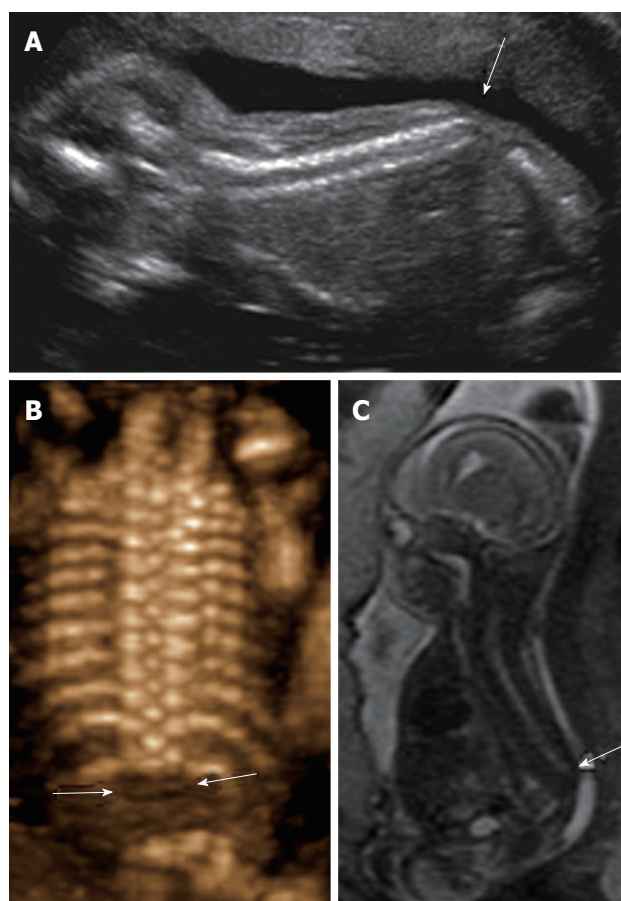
Sacral agenesis. 2D sagittal grayscale ultrasound (A), coronal 3D ultrasound (B), and parasagittal T1 weighted image (C) of a 19 wk fetus demonstrate absence of the fetal spine caudal to T12 (arrows), consistent with sacral agenesis/caudal regression syndrome. The mother was known to have type 1 diabetes, a risk factor for this condition.
